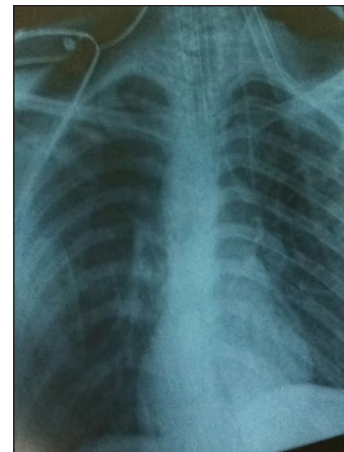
Postoperative X-ray chest AP view. Near total haziness in right lung field
